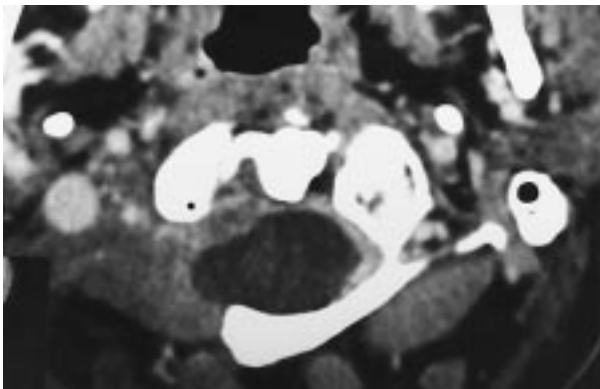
Post-operative CT scan in a case of rheumatoid arthritis. Notice the significant drilling on the right side (asterisk)
